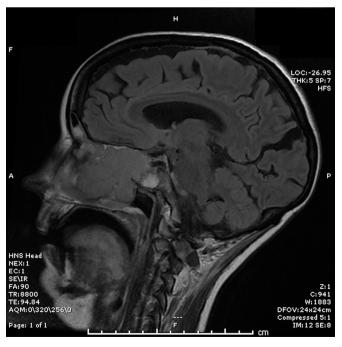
T2-weighted fluid-attenuated inversion recovery axial MRI demonstrating a large sinonasal tumour within the left nasal cavity. There is encasement and narrowing of the left internal carotid artery in the anterior aspect of the left cavernous sinus.
